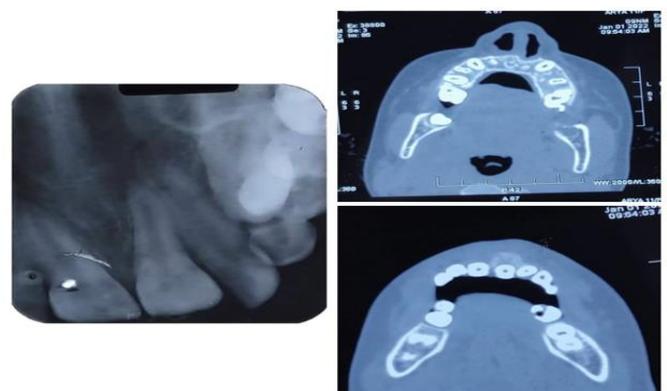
Intra oral periapical radiograph without any significant changes and CECT scan showing well
